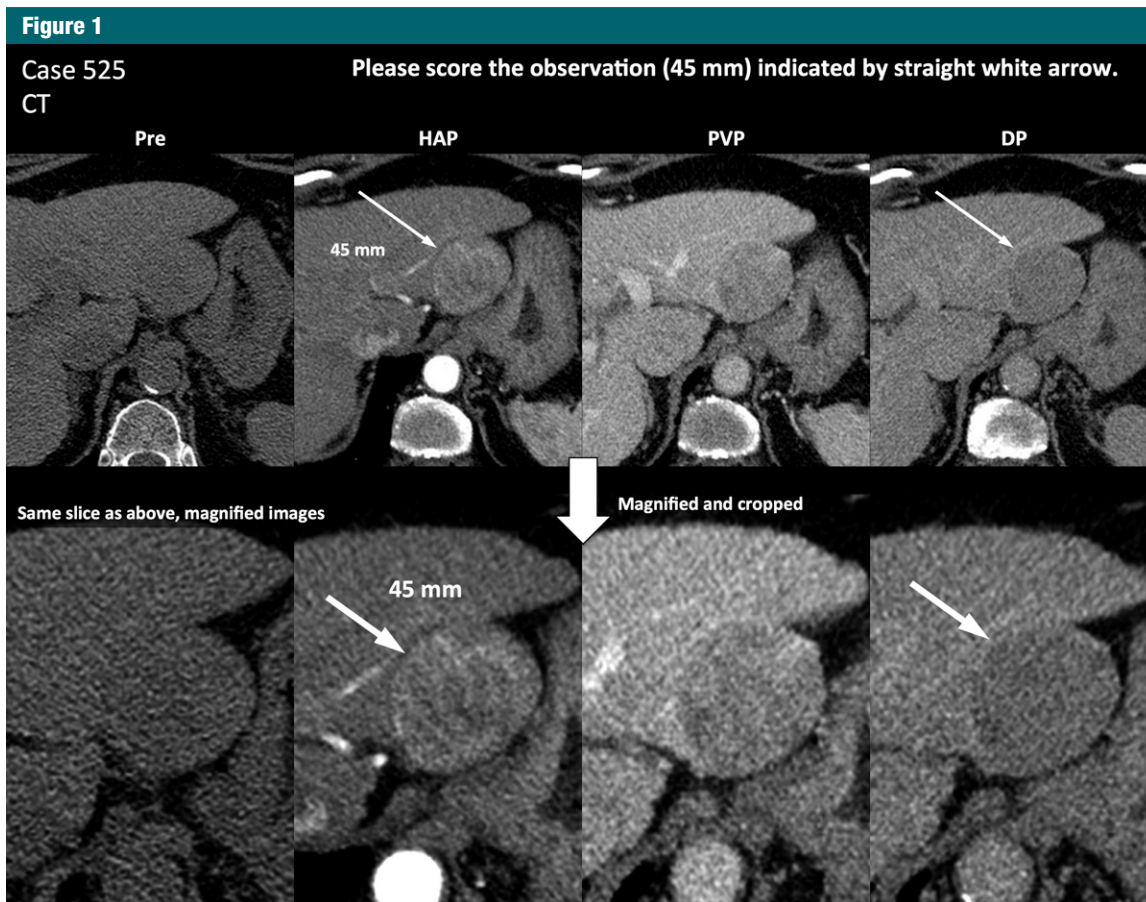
CT image set shows an LR-5 observation (arrows) with high agreement. The image set is exactly as it was presented to reviewers. All (100%) reviewers chose LR-5 as the category. DP = delayed phase HAP = hepatic arterial phase, Pre = precontrast, PVP = portal venous phase.
